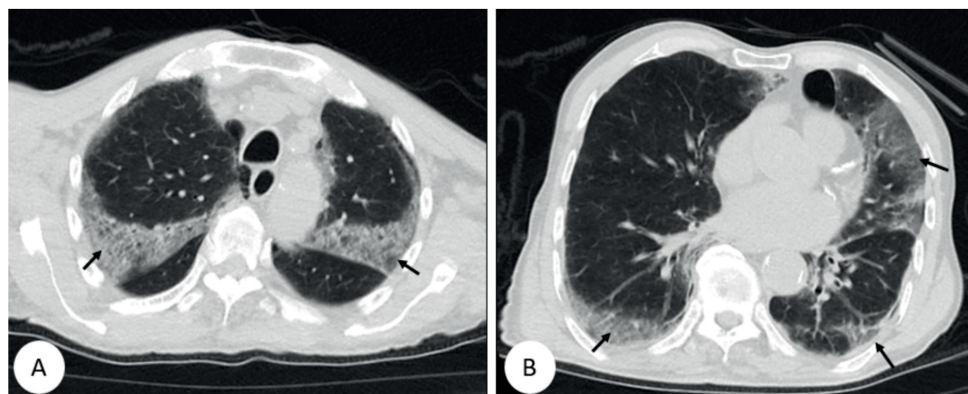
Axial section non-contrast computed tomography showing widespread ground-glass opacities and crazy paving patterns in the bilateral lungs (arrows).
